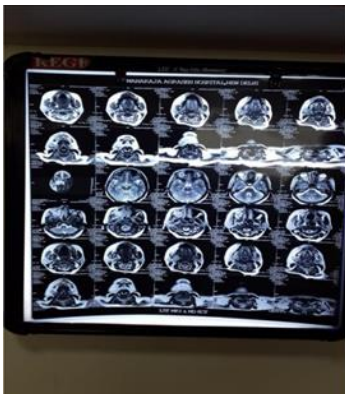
MRI of the face, which showed area of soft tissue inflammation involving subcutaneous tissue of right side of face extending upto right parapharyngeal space and right maxillary sinusitis.
